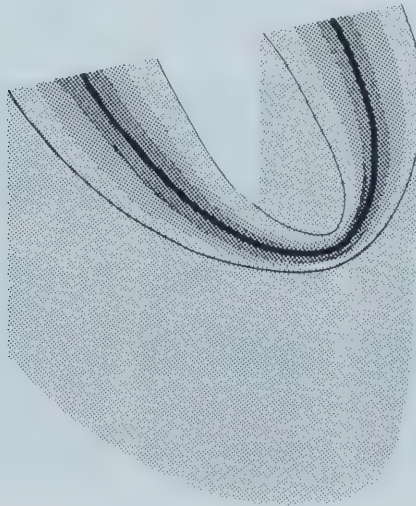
Focal Trough in Panoramic Radiography. The dark line in the middle of the focal trough represents the central plane. The further an anatomic structure is positioned relative to the central plane, the greater the amount of distortion and blurring on the radiographic image. (From Goaz PW: White SC 1994; 12: 245)
